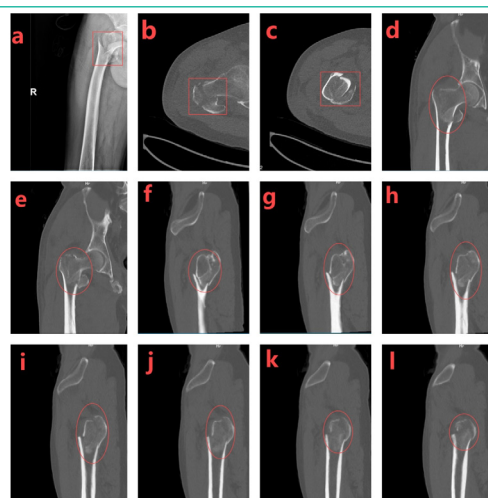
X-ray examination and CT scan showed a comminuted intertrochanteric fracture of the right femur, a fracture of the greater as well as the lesser trochanter of the femur, and swelling of the surrounding soft tissues.
